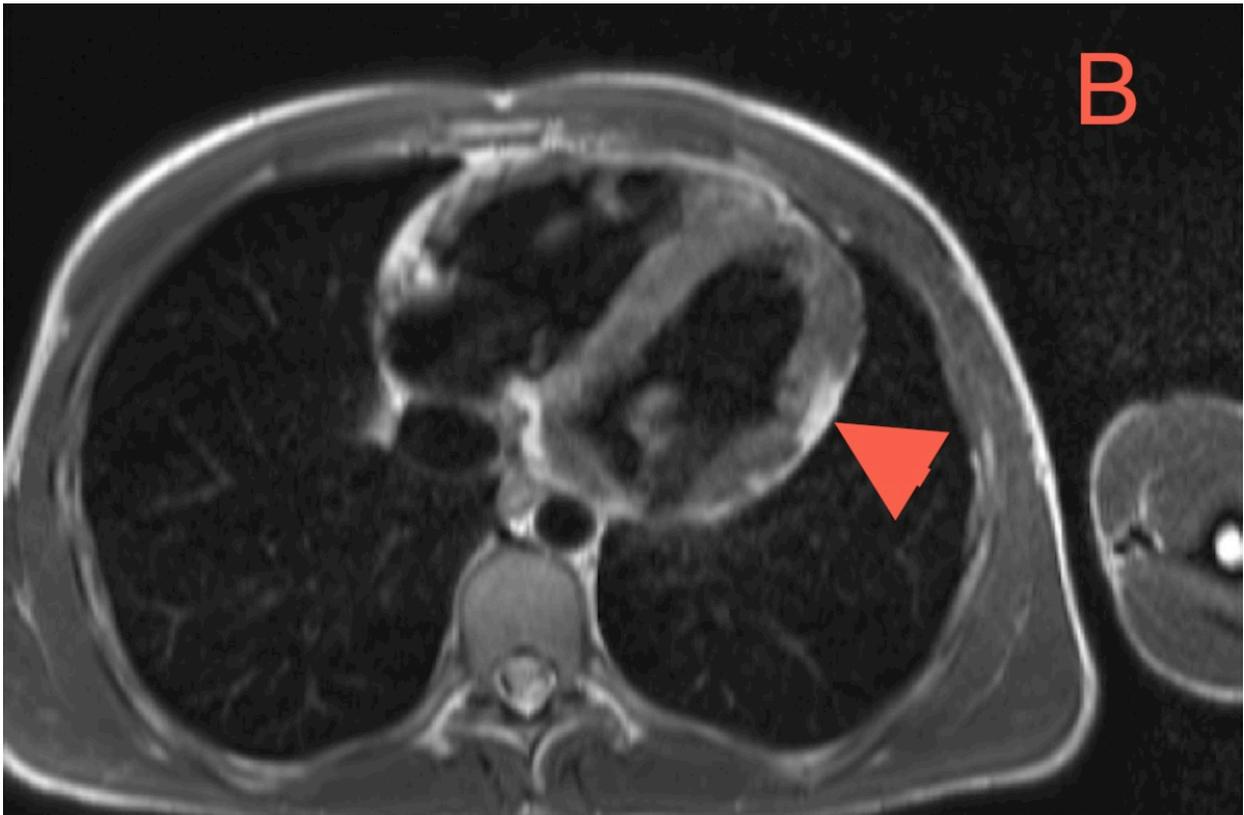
ARVC. Axial T1-weighted black blood image (B) demonstrates fat deposition (arrowhead) in the LV free wall.
